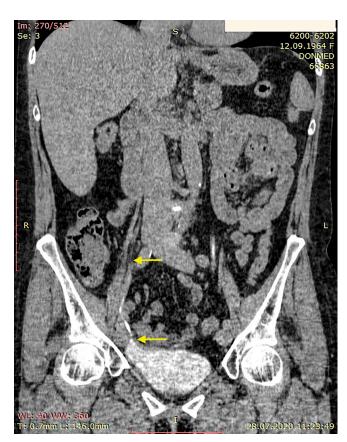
Contrast enhanced computed tomography, post-surgery. Arrows mark the boundaries of the replaced ureter segment
